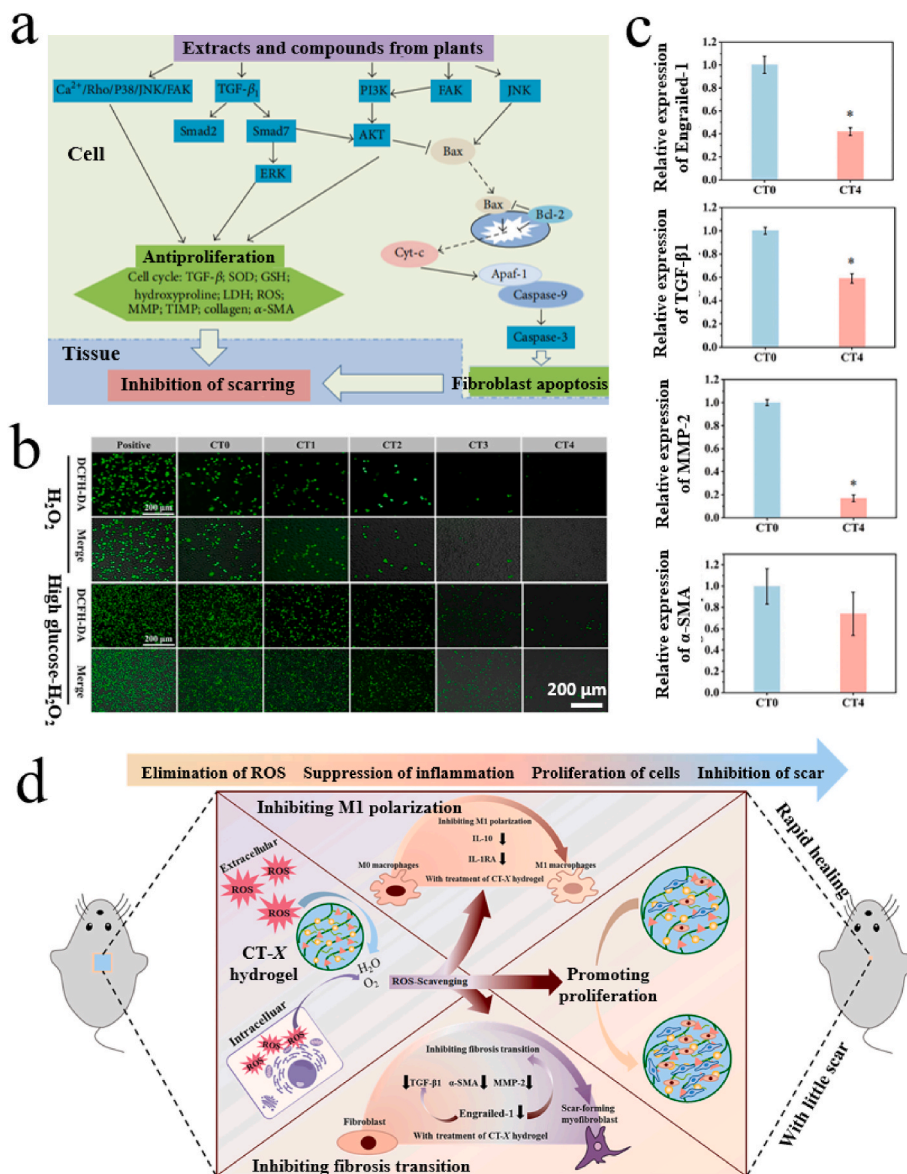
(a) Common anti-scarring mechanisms of medicinal plant components [163]. Copyright 2015, Qi Ye et al. (b) Scavenging ROS with CT-X hydrogels *in vitro*. (c) The inhibition effect of CT-X hydrogels on scar formation. (d) The mechanism of inhibiting scar formation by CT-X hydrogels [169]. Copyright 2023, Elsevier.
